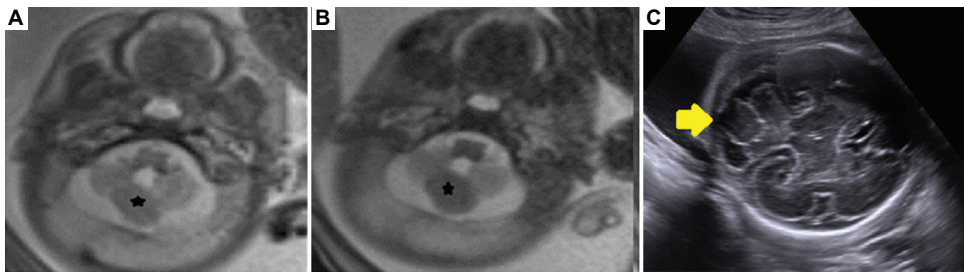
Multimodal imaging of a posterior fossa extra-axial mass-like lesion. (A) Axial HASTE and (B) TRUFI images demonstrate a posterior fossa extra-axial mass-like lesion with signal characteristics resembling G-ray matter (black star). (C) An ultrasound image confirms the presence of the same extra-axial lesion across different imaging modalities (yellow arrow).
